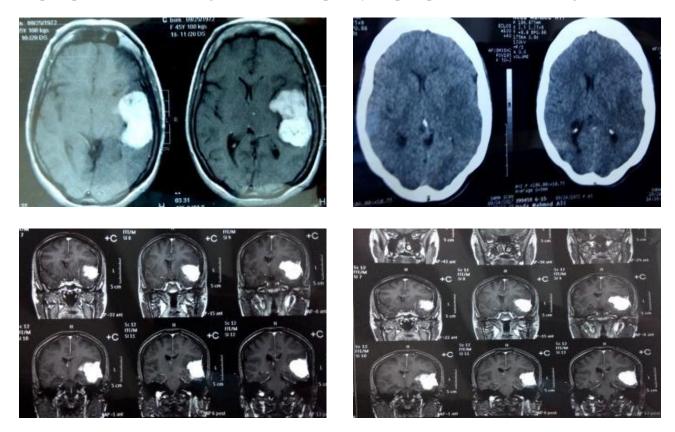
Preoperative CT brain axial cuts, and preoperative enhanced MRI brain axial and coronal cuts
